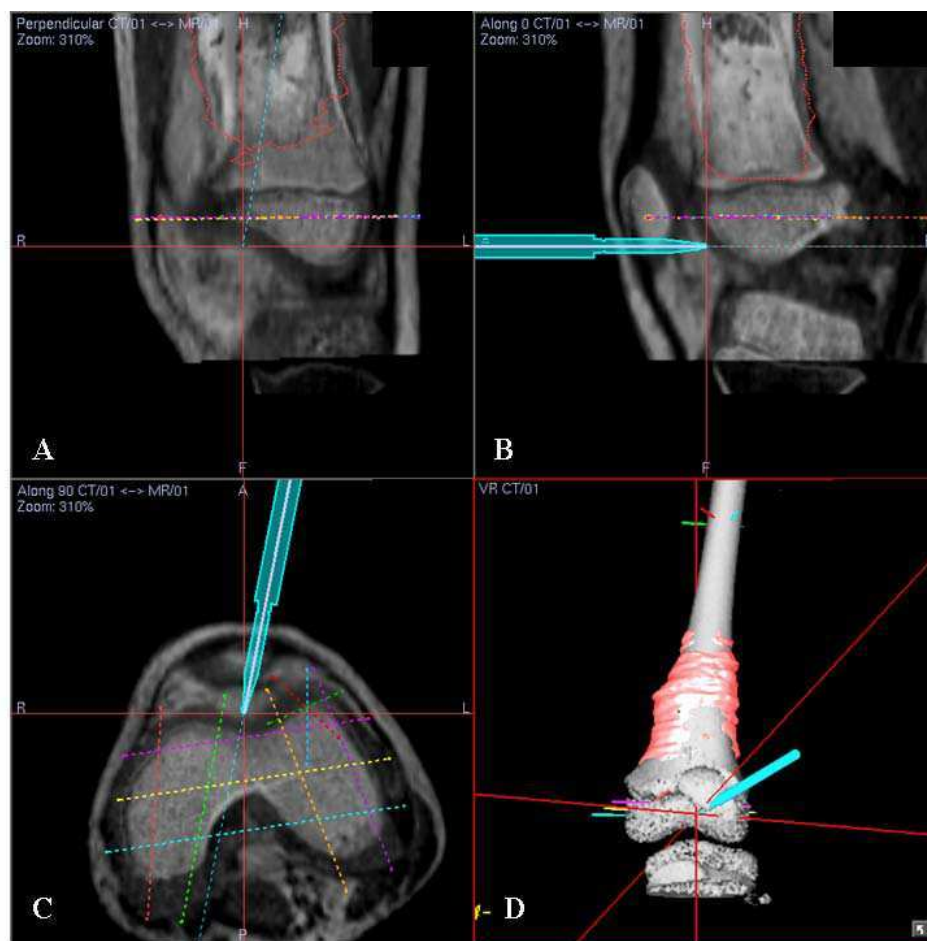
(A) Coronal, (B) sagittal, (C) axial sections of CT/MR fused images and (D) 3-D bone tumor model for Patient 9 with left distal femur osteosarcoma are shown. After performing image-to-patient registration using paired points and surface matching at the surgery, we assessed the real-time matching between operative anatomy and the virtual images by running the registration probe on bone surface or by checking some anatomic landmarks. The registration was judged to be accurate and acceptable for subsequent navigation procedure as the tip of navigation probe matched well with the cartilage surface of distal femur
